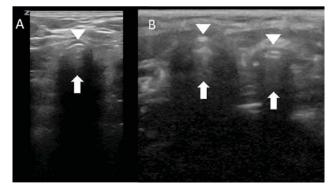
(A) Ultrasonographic image of tracheal intubation. Only one A–M interface (arrowhead) with comet-tail artifact (arrow) and posterior shadowing is observed. (B) Ultrasonographic image of esophageal intubation. Two A–M interfaces (arrowheads) with comettail artifacts (arrow) and posterior shadowing are observed. This is also referred to as the "double tract" sign.
